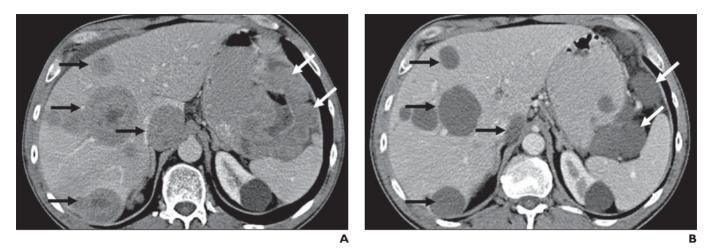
CT attenuation decrease in gastrointestinal stromal tumor (GIST) treated with tyrosine kinase inhibitor imatinib.
